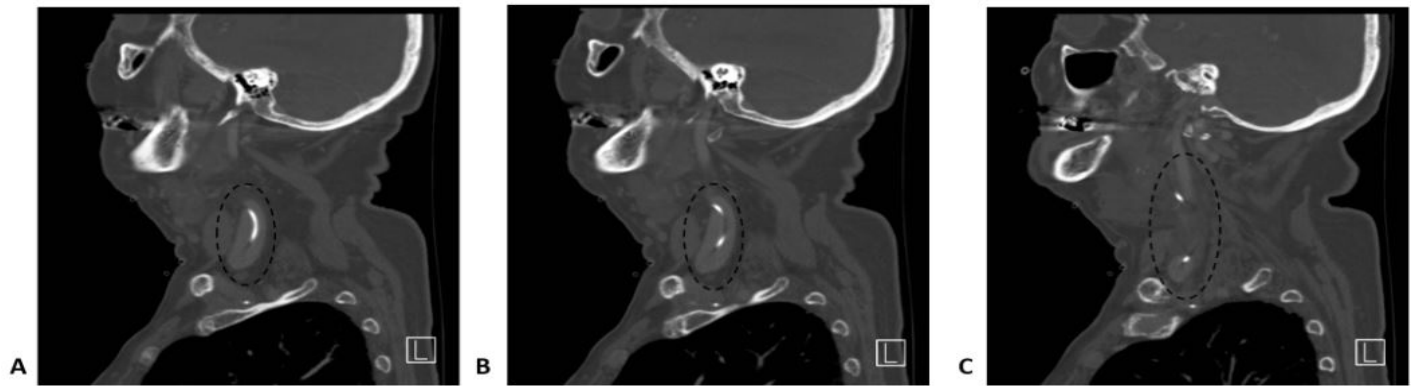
Sagittal computed tomography with contrast of the patient's left neck (A superficial to C deepest) demonstrating perforation of the internal jugular vein with the peripherally inserted central catheter (circles)
